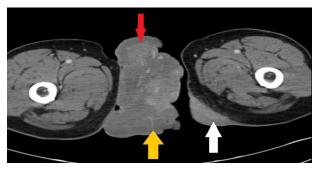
Computed tomography scan showed a 15×9 cm sized soft tissue mass in the scrotum (yellow arrow) and penis which has extended into the fascial area of left inner thigh (white arrows). Penile glans (red arrow) is trapped in within the mass.
